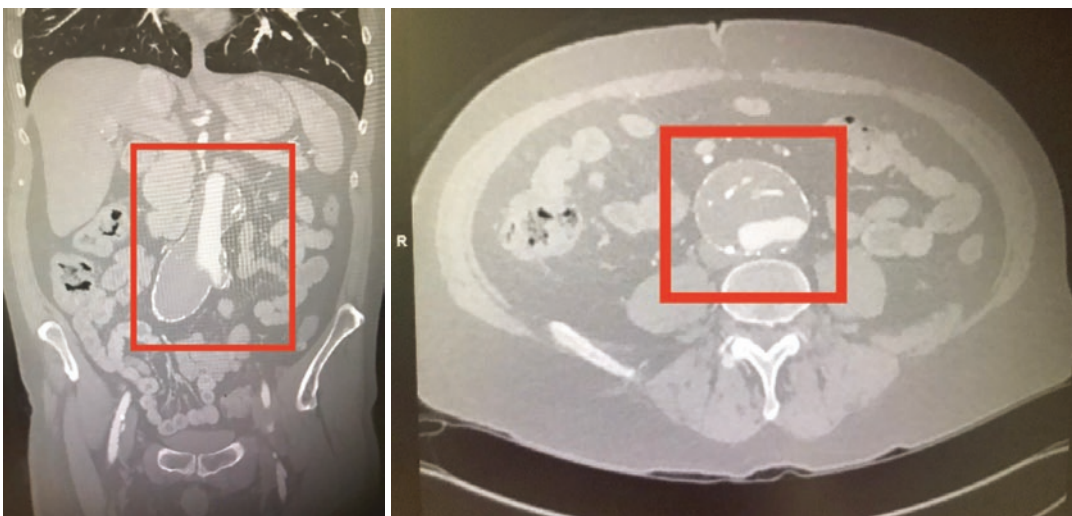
Infrarenal AAA pre-EVAR with heavy thrombus (DARK) and atherosclerotic burden (calcification in wall of aorta) on CT imaging
